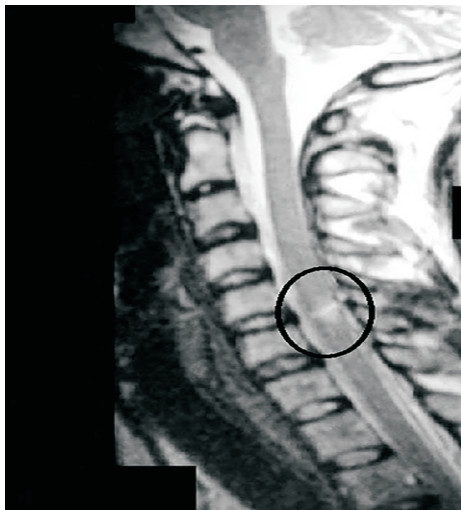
Sagittal Film of MRI of the Cervical Spine revealing cord contusion at CV₆ level.
